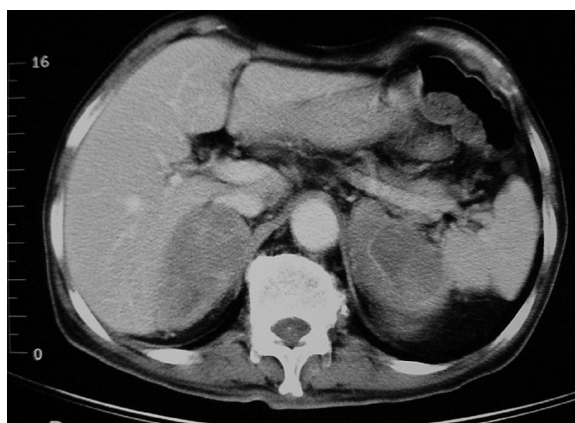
Abdominal CT scan with intravenous enhancement showing bilateral adrenal mass lesions.
